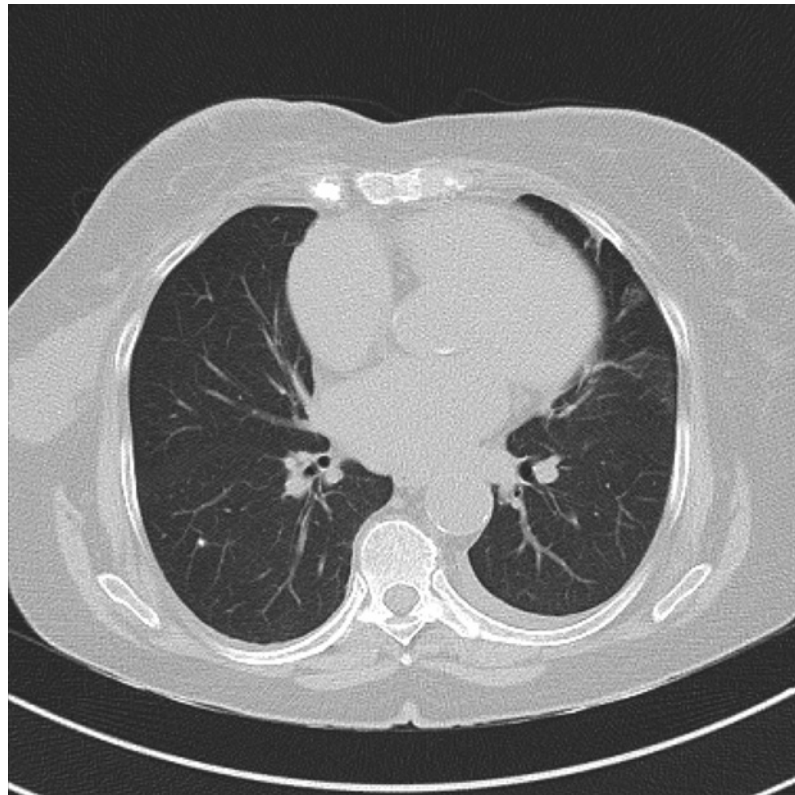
CT angiogram of the thorax performed 2 weeks after radical right mastectomy.
